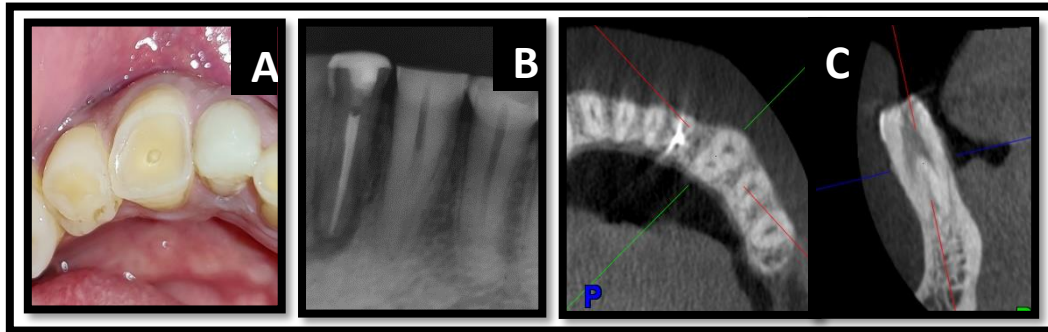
A.Preop clinical View B & C. Preop IOPAR & CBCT showing two roots and two root canals
